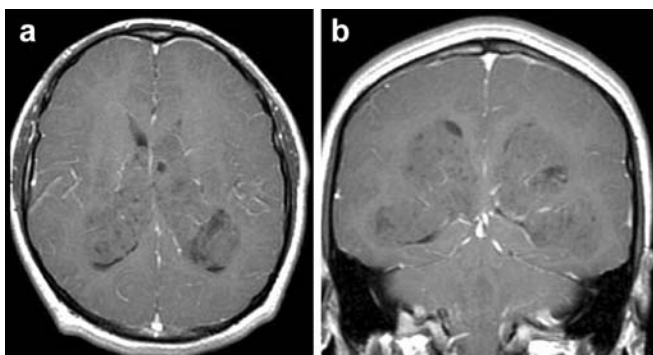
Axial (a) and coronal T1-weighted (b) post-contrast-enhanced images demonstrate an intraventricular mass with minimal enhancement occupying the lateral ventricles and extending into the temporal horns
